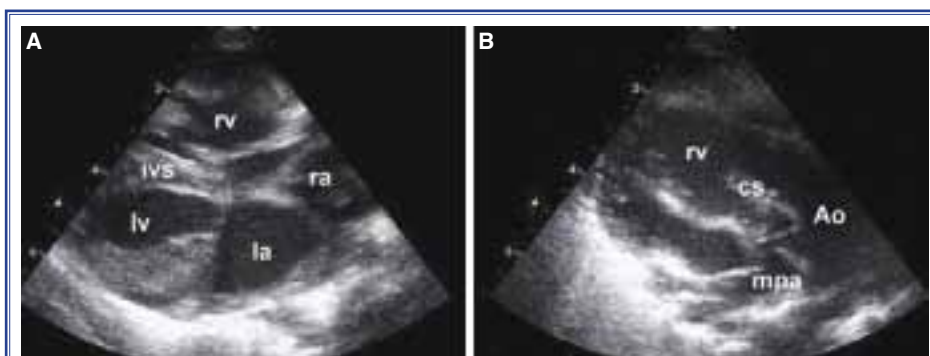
Double outlet right ventricle with intact ventricular septum is monitored on the 2D echocardiography in the apical four-chamber and parasternal long-axis study. (A) Intact ventricular septum and hypoplastic left ventricle with mitral valve are shown. (B) Both great arteries arise from only the right ventricle; the aorta is to the right and anterior to the pulmonary artery. la: Left atrium; ra: Right atrium; lv: Left ventricle; rv: Right ventricle; cs: Conus septum; ivs: Intact ventricular septum; Ao: Aorta; mpa: Main pulmonary artery.
